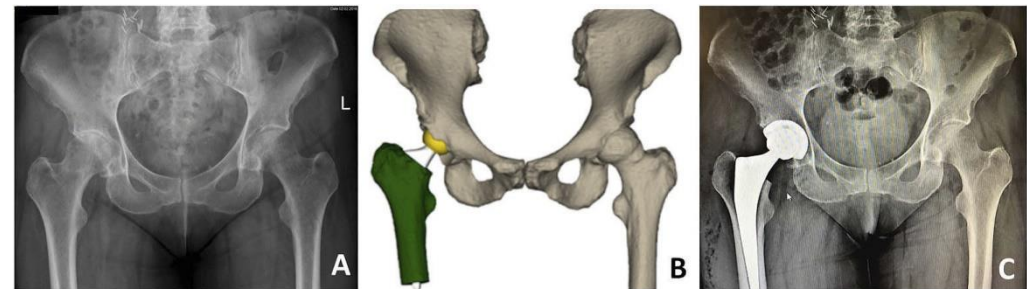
3D-CT planning with a dedicated software package (medICAD©, HecTec GmbH). A) Most if not all THA planning software have 3D reconstruction functionality and allows positioning of the acetabular component on the coronal and sagittal 2D views. B) This is also possible with stem anteversion and position of the femoral head.
